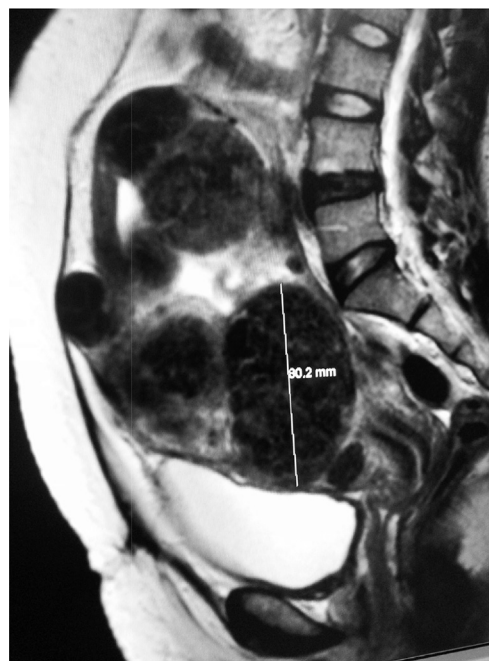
MRI T2 WEIGHTED IMAGE – sagittal image of multiple fibroids.
